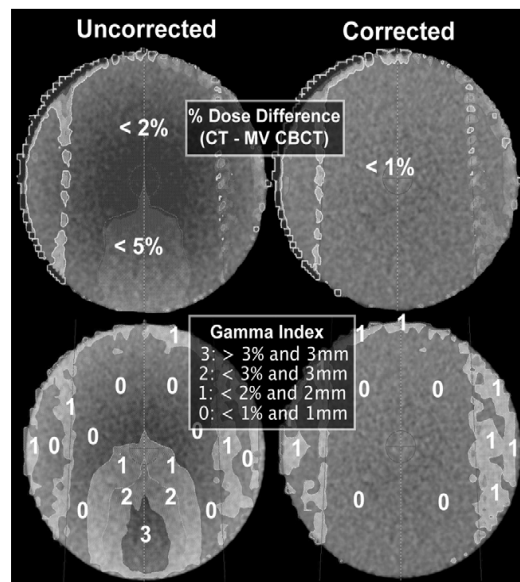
(Top) Dose percentage differences (CT-megavoltage cone-beam CT [MVCBCT]) and (Bottom)  $\gamma$  indexes for head-size water cylinder (Left) uncorrected and (Right) corrected for uniformity.
